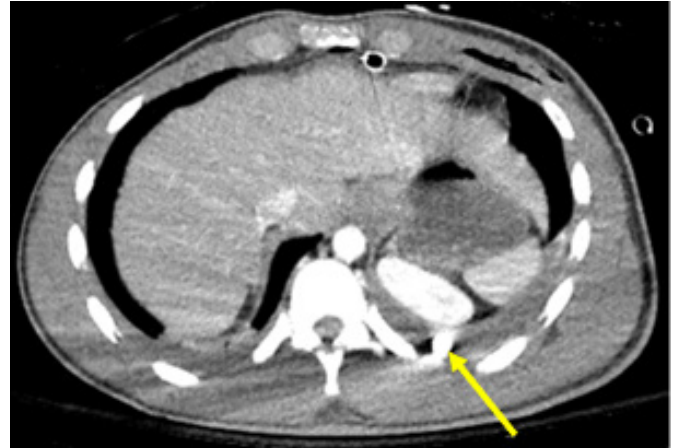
Axial CT image of patient with trans-mediastinal gunshot wound depicting bullet location. Solid yellow line indicates the position of the bullet in the left diaphragmatic sulcus, posterior to the left kidney on CT scan.
